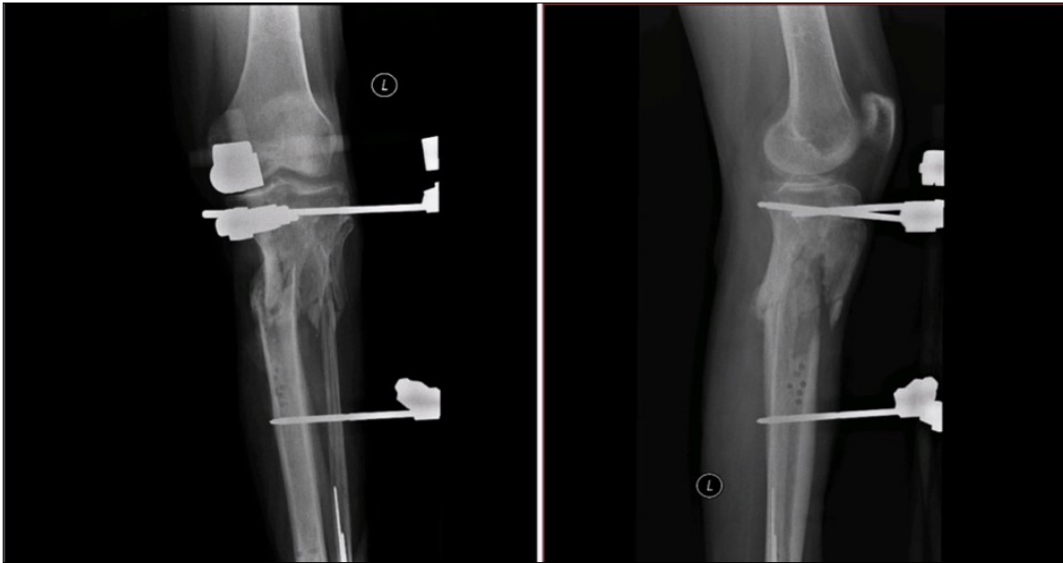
c) 9.2.2016 X-ray
